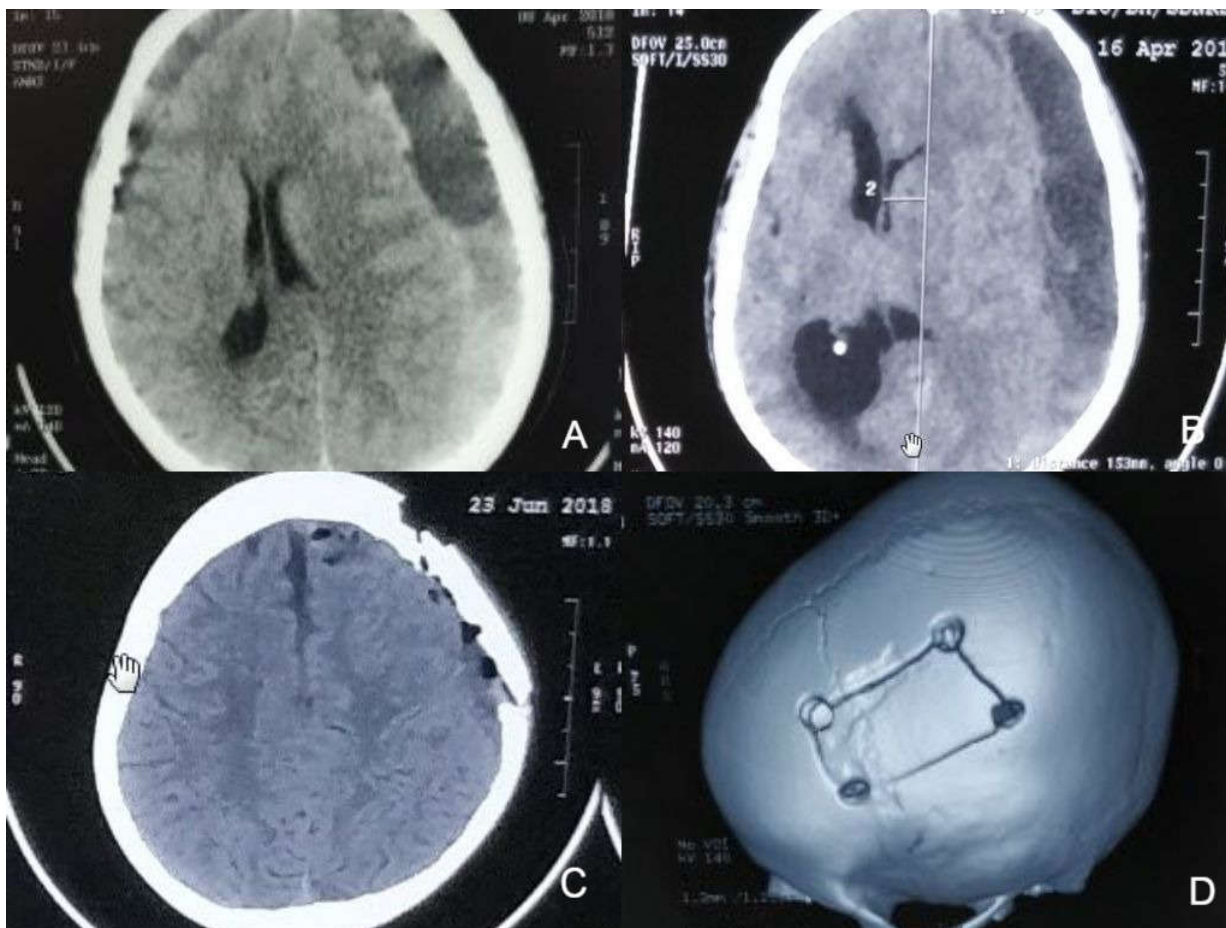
[A] Bilateral cSDH with intrahaematomal membranes on the left side. [B] Left Fronto-parietal cSDH with intrahaematomal membranes. [C] Post-operative CT scan following a small craniotomy for cSDH. [D] 3D reconstructed CT scan image of the craniotomy flap of the same individual in Fig 1.
